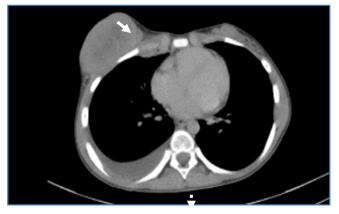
Axial post contrast CT images showing bilateral breast masses (larger on the right side) (Solid arrows). Right pleural effusion (dotted arrow) is also noted
